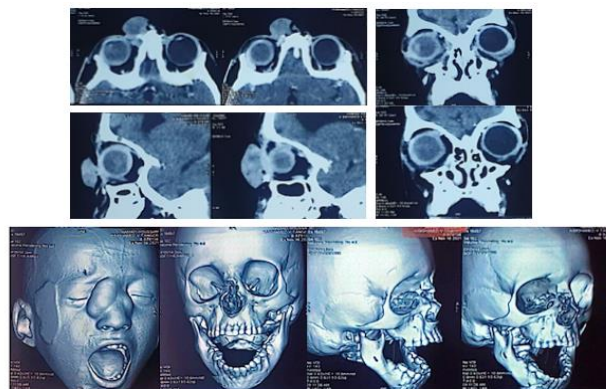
CT scan images of the neurofibroma nasal tumor in axial, coronal, sagittal and 3D sections
